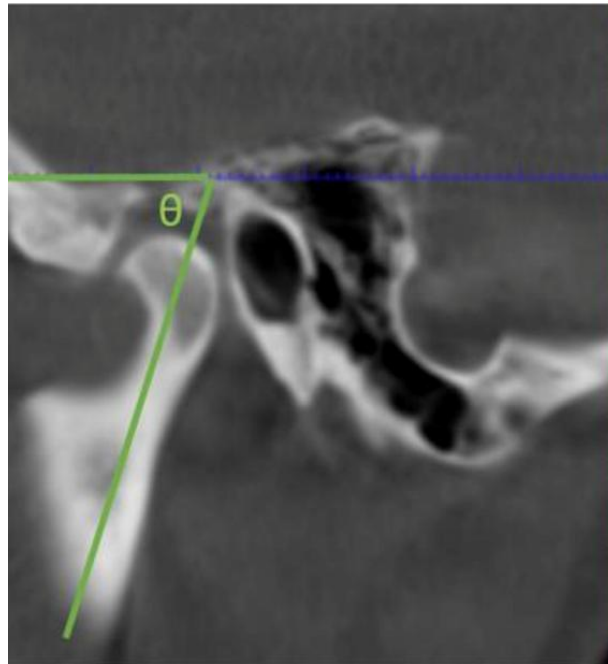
Assessment of condylar axis angulation on sagittal CBCT section.
